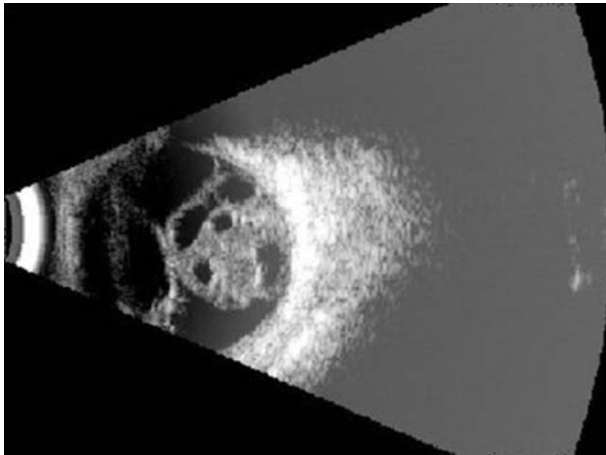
B-scan ultrasonography of left eye. Acoustically solid lesion, 12 mm on maximal basal diameter and 12 mm high, with multiple, well-defined, cyst-like cavities and associated retinal detachment.
